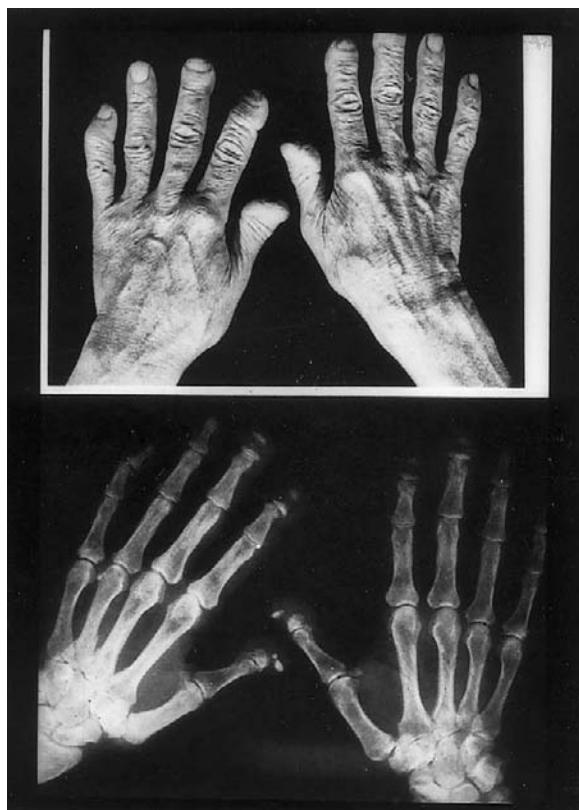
Photograph and radiograph of hands of a patient with marked hyperparathyroid bone disease. Marked periosteal bone erosion in terminal phalanges has resulted in "pseudoclubbing." From Levine *et al.*, (1982).
